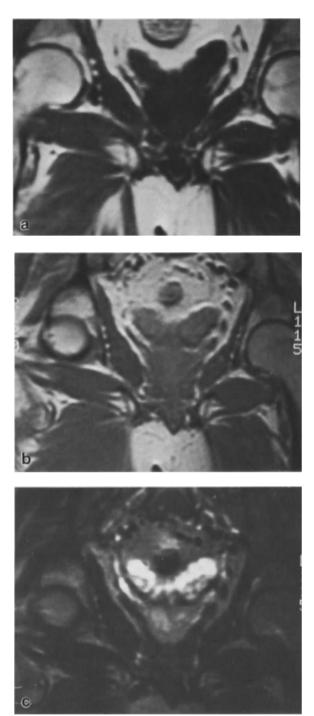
MRI of the pelvis. Coronal scan showing a normal seminal vesicle. a T1, TR 600, TE 12; b PD, TR 2000, TE 20; c T2, TR 2000, TE 80
